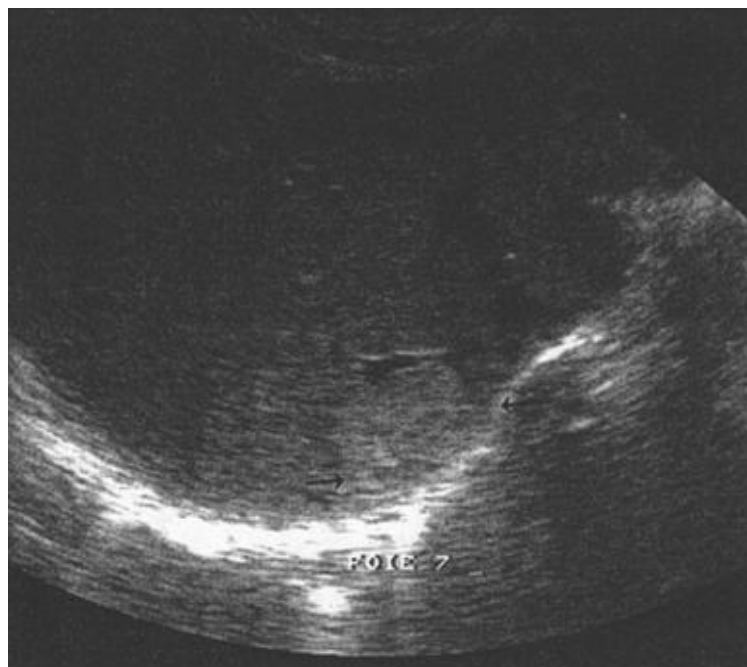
Hepatic ultrasound: hyperechoic, homogeneous, well-defined, subcapsular image = Hepatic hemangioma
